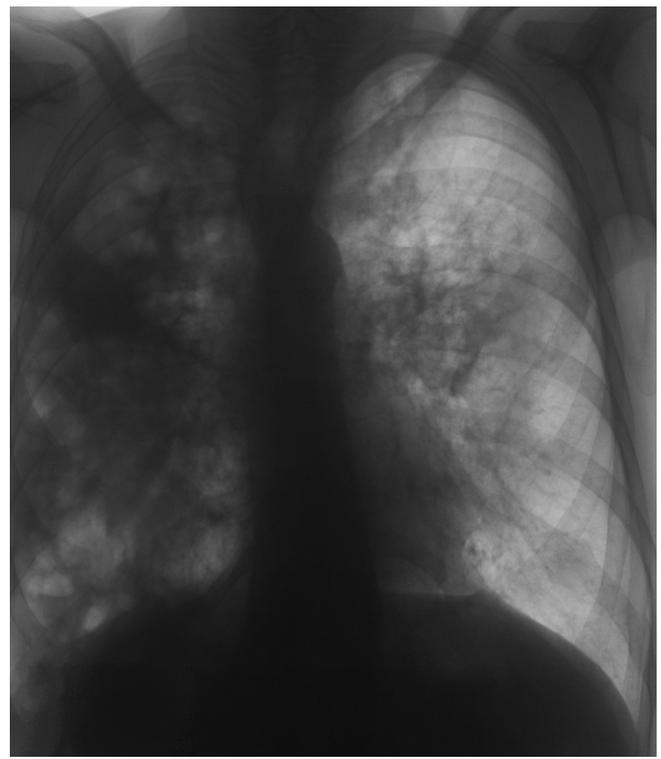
Chest X-ray four months after starting TB treatment
